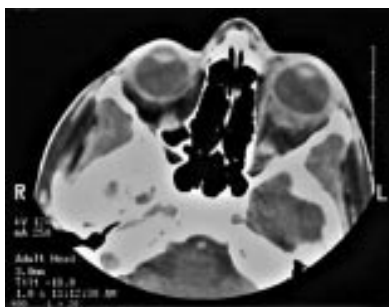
CT scan showing bilateral soft tissue thickening of the posterior coats of the globe and periocular tissues. This is predominantly intraocular and adjacent to the left globe. The extraocular muscles appear normal.
